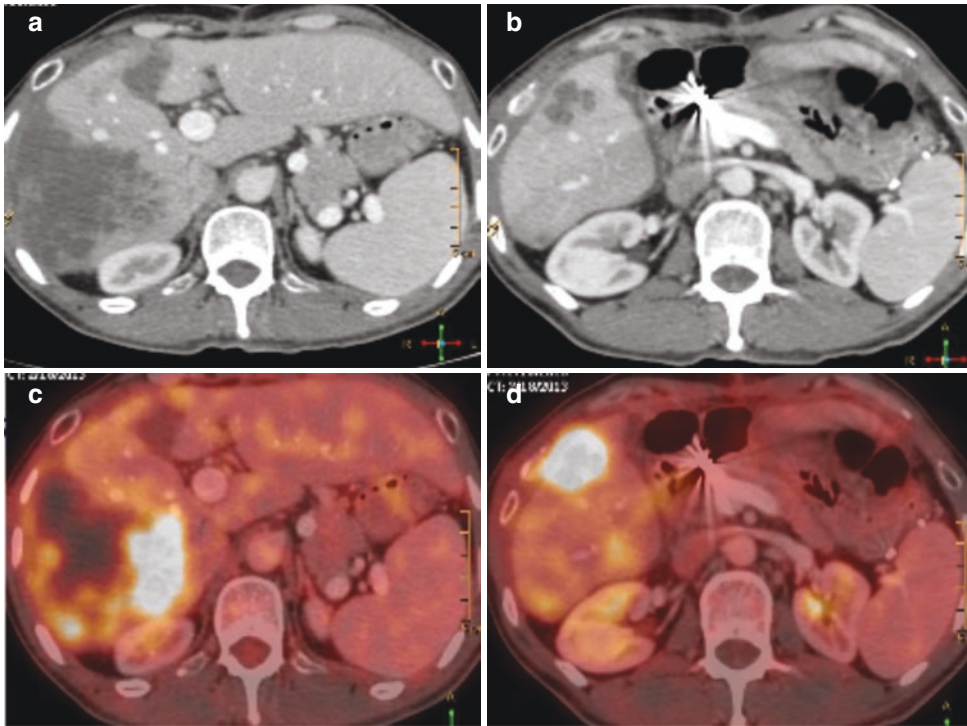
(a–d) A 50-years old patient of colorectal carcinoma with liver metastases. PET—CECT images show enhancing lesions in segment V and VI with areas of FDG uptake
